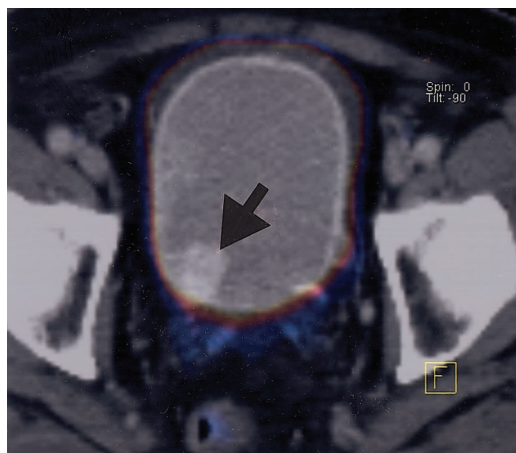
The CT portion of a PET-CT study can demonstrate diseases besides the primary malignancy that may be important in patient care. (a) FDG PET-CT was performed after surgical resection of the primary tumor in a patient with colorectal carcinoma to evaluate for recurrence. Axial fused FDG PET-CT image shows extensive segmental occlusive and subocclusive pulmonary emboli (arrows), findings that would be missed with PET. (b) FDG PET-CT was performed for staging in a patient with Hodgkin lymphoma. Axial fused FDG PET-CT image of the brain shows an aneurysm of the right middle cerebral artery (long arrow). Intense physiologic metabolism of the brain would mask this lesion on PET images. Short arrows = misregistration due to patient motion. (c) FDG PET-CT was performed for restaging in a 71-year-old man with melanoma who experienced new-onset hematuria. Axial fused FDG PET-CT image of the pelvis shows a polypoid bladder mass (arrow), which was the cause of the hematuria.
